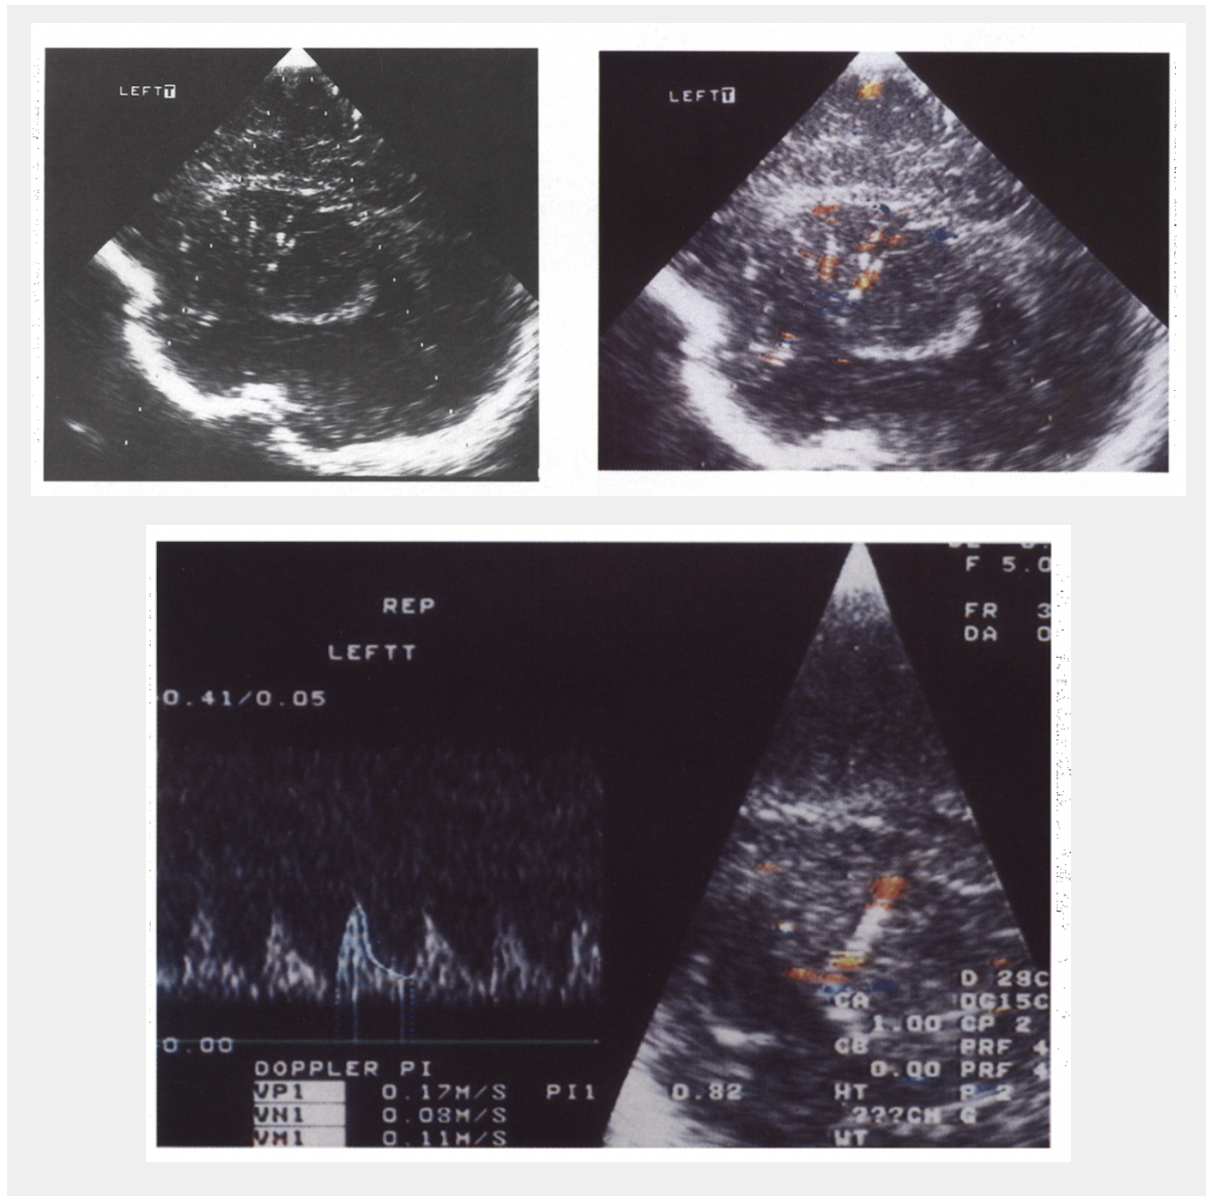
Doppler flow imaging studies demonstrating blood flow velocity wave within echogenic lenticulostriate arteries. Adapted by Cabanas et al, 1994
